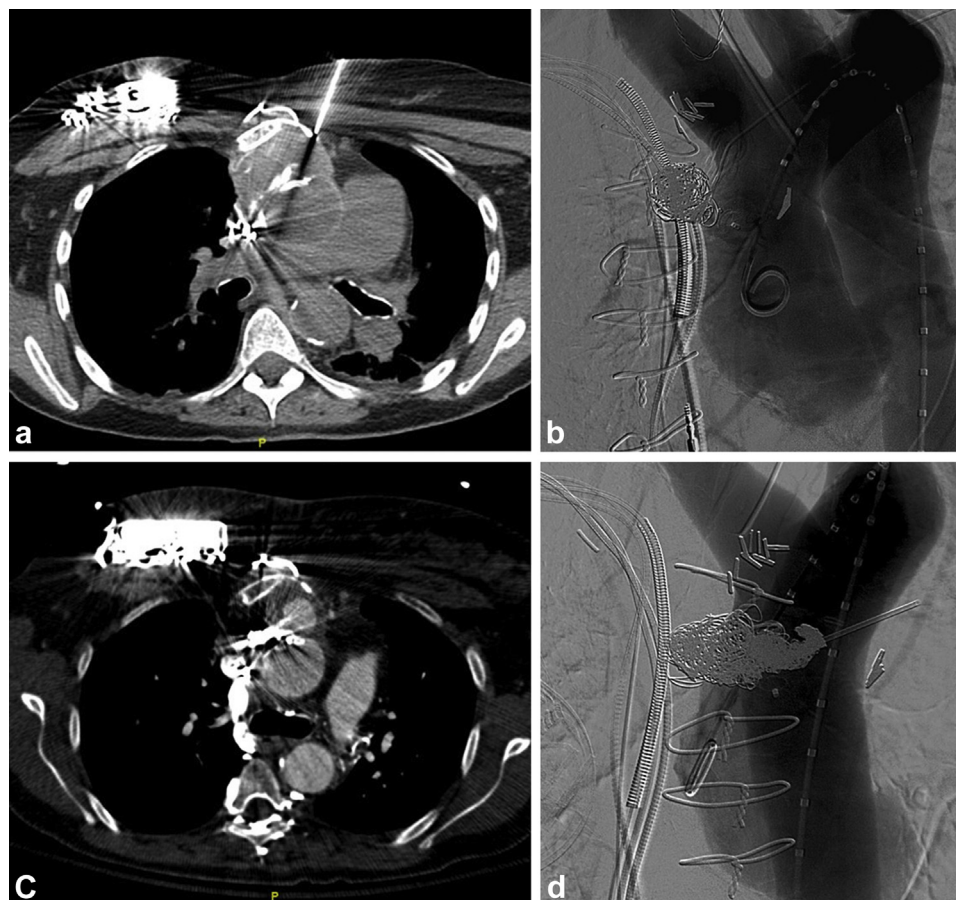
Percutaneous transthoracic approach in patient 1. (a) Axial nonenhanced CT. Percutaneous transthoracic 19-gauge Chiba needle (arrowhead) is shown approaching the ascending aortic pseudoaneurysm (arrow) in a patient with a history of bicuspid aortic valve and surgical repair of an ascending aortic aneurysm. A Renegade STC-18 microcatheter and V-18 microwire (Boston Scientific, Marlborough, Massachusetts) were used to secure access before transferring the patient from the CT scanner to the interventional radiology suite (not shown). A septal occluder device (curved arrow) is partially visualized, related to prior attempted closure of the AAP at an outside facility. (b) The AAP was embolized through the transthoracic Chiba needle by using Interlock coils (Boston Scientific), seen on digital subtraction angiography (DSA) (broad arrow). Absorbable collagen-based hemostatic material slurry was then used to seal the pseudoaneurysm sac and to embolize the percutaneous needle track to the level of the sternum. (c) Contrast-enhanced CT at the follow-up examination 2 months later shows a small area of persistent filling within the pseudoaneurysm (arrow). Coils (broad arrow) and the existing septal occluder device (curved arrow) are partially seen. (d) Postembolization angiography after repeated percutaneous embolization shows enlargement of the coil pack (broad arrow) and no further filling. Contrast-enhanced CT performed 3 days after the second procedure demonstrated no contrast enhancement of the AAP (not shown).
